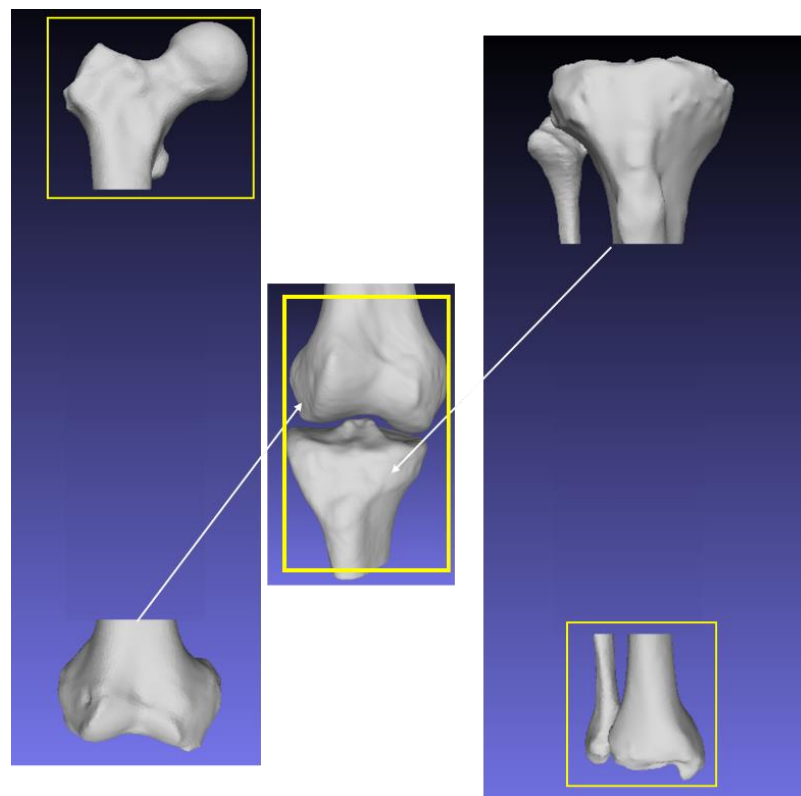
Scanning the regions of interest of the lower leg. A localizer sequence can be used to select the field of view (the lower leg). Then, femur head can be scanned first, the femur shaft can be skipped, and the knee joint can be scanned. Note that it is important to maintain the same scanning setup and field of view; otherwise, scans will be distorted. The anthropometric distance can be maintained between, for instance, the femur head and the distal femur bone with the same setup and localizer sequence. Finally, the tibial shaft can be skipped, and the distal tibia can be scanned similar to the femur head. Eventually, the regions within the yellow rectangles will be output of the MRI scan which captures the missing data needed in this study's protocol.
